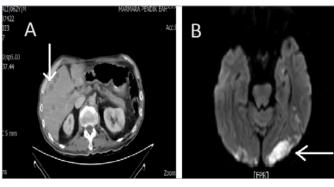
(A) Abdominal CT shows several hypodense lesions (metastases) in the liver. (B) Brain MRI shows embolic appearance in cerebral hemispheres showing diffusion limitations.
